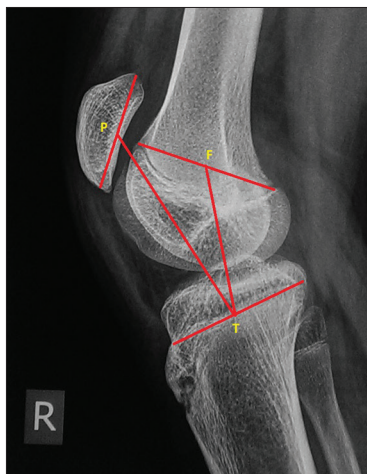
Preoperative lateral radiograph of knee in maximal extension showing calculation of Koshino Index. Here, the Koshino Index (PT/FT) = 1.44 indicating patella alta
